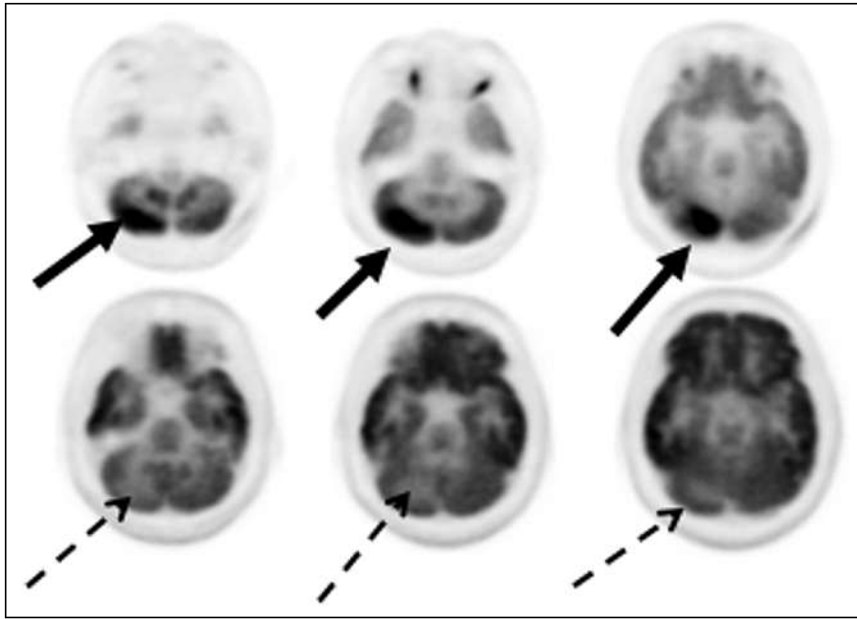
^{18}F -FDG PET scans of 15-y-old boy with anti-*N*-methyl-D-aspartate receptor encephalitis. (Top) Focal intense hypermetabolism in right cerebellar cortex (solid arrows) and diffuse hypometabolism of bilateral cerebral hemispheres. (Bottom) Subsequent focal hypermetabolism in right cerebellar cortex (dashed arrows), corresponding to initially hypermetabolic region. (Reprinted with permission from Sage (29).)
